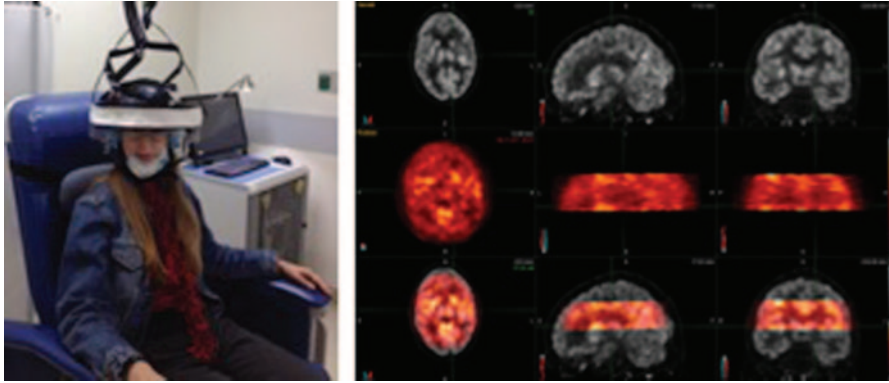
Helmet.PET [10-12], an upright wearable brain PET with limited axial field of view, allowing for wide head motions. On the left a picture is shown of a sitting volunteer wearing the Helmet.PET detector ring and showing that the PET imager moves with the head even during wide-angle movements. The imager has a limited ~ 5 cm vertical FOV. Right: the pilot result of FDG brain imaging in a volunteer patient, compared to images obtained with the standard Siemens PET/CT. The images from the dedicated Helmet.PET are overlaid on the CT images from the PET/CT scanner.
